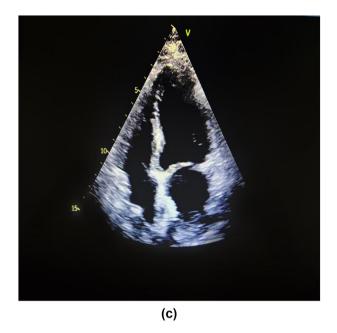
(a) Intraoperative appearance of the incised interatrial septum from right atrial side showing the presence of clot. (b) Intraoperative appearance of a large empty interatrial space after the removal of clot. The arrow directed at interatrial space. (c) Postoperative transthoracic echocardiography on day 10 showing clear left atrium, thick interatrial septum with pericardial patch.
